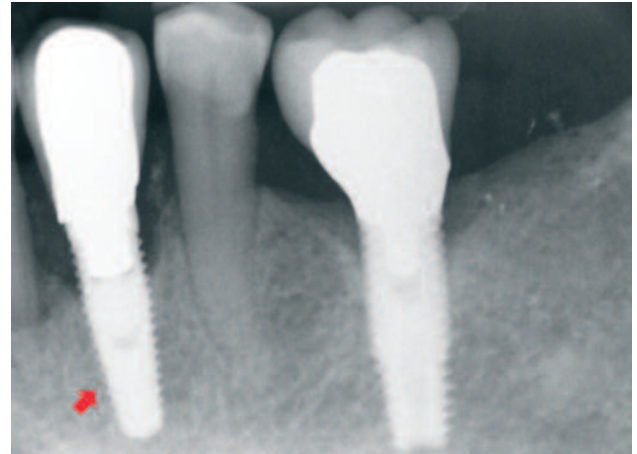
Initial radiograph. We can observe the poor periodontal situation of the antero-interior face. In addition to removal of the implant in position 34, we decided to extract the affected teeth and place implants in the area.
